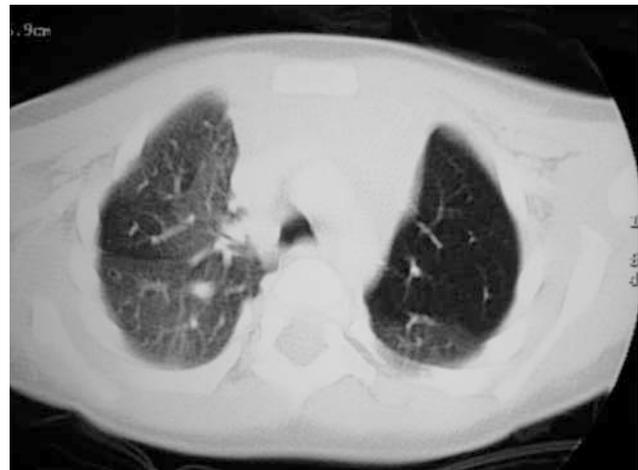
CT scan reveals hyperlucent left upper and lingular lobes with reduction in lung volume and attenuation of arteries (Case 3).
